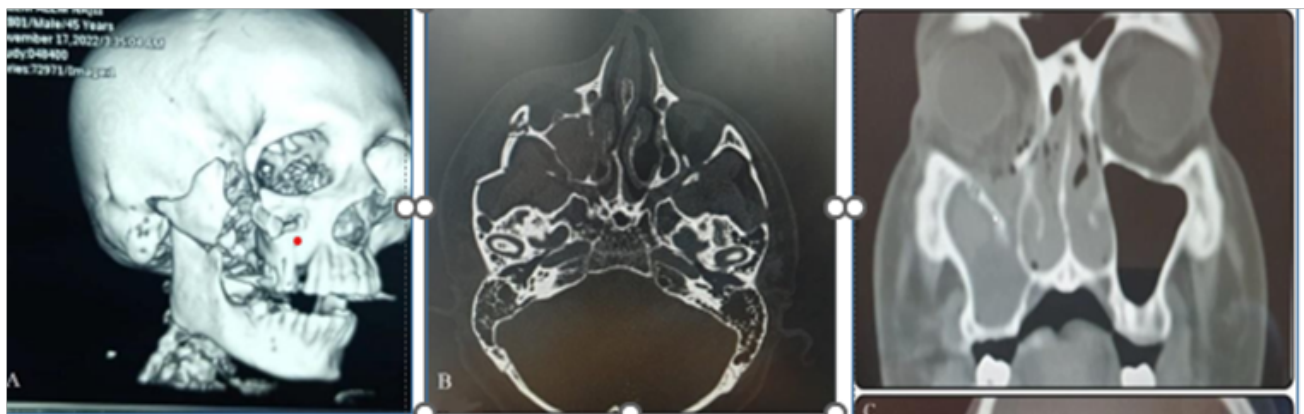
CT scans for different patients with concomitant head and maxillofacial trauma.
